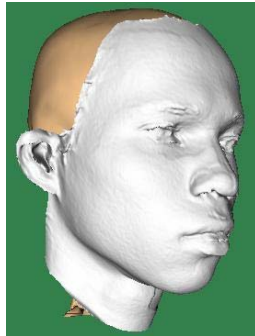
Soft tissue (laser scan) superimposed of hard tissue (CT data)
